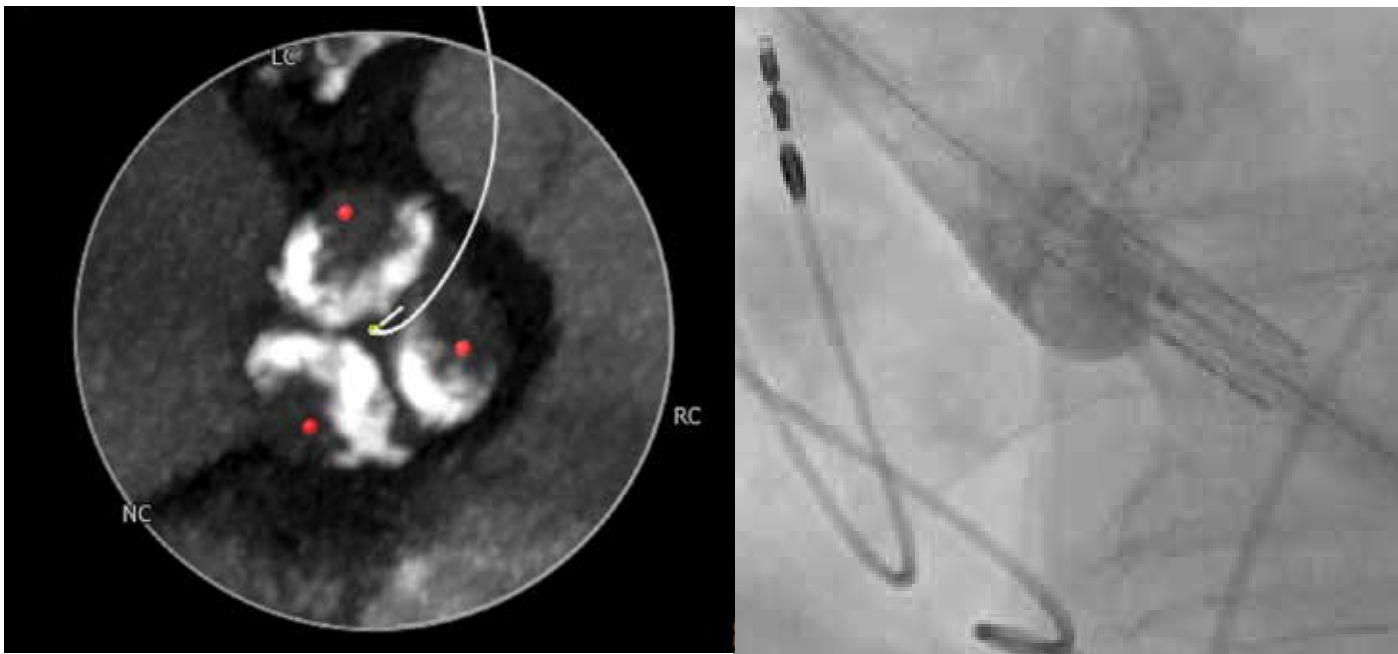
CT view of valvular calcification pattern and positioning of the SAPIEN 3 valve before deployment under fluoroscopic view.
